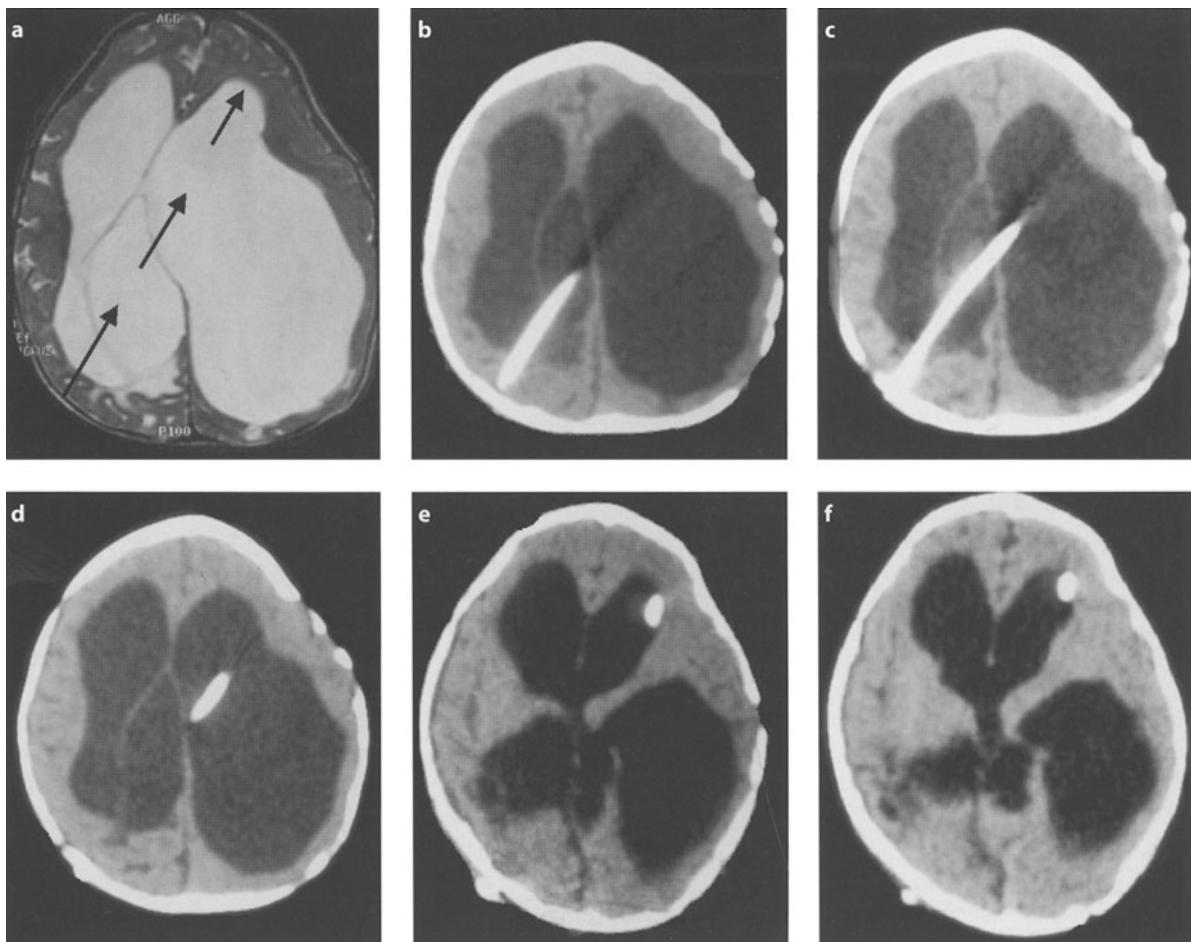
a-f. One-year-old boy, no available history on the prenatal and neonatal period. a Four loculated compartments are visible on the MRI; the ideal trajectory for perforation of all the septations in a straight line is carefully chosen on the scan (arrows). b-f Postoperative CT: all the septa have been perforated under endoscopic control and a ventricular catheter has been inserted under endoscopic guidance across the fenestrations after multiple holes have been made along it. The tip is inserted into the most distal cavity in the left frontal horn (f). The ventricular catheter is then connected to a peritoneal shunt system
